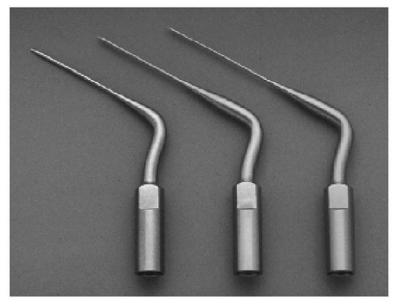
Titanium CPR ultrasonic tips 6 through 8.
